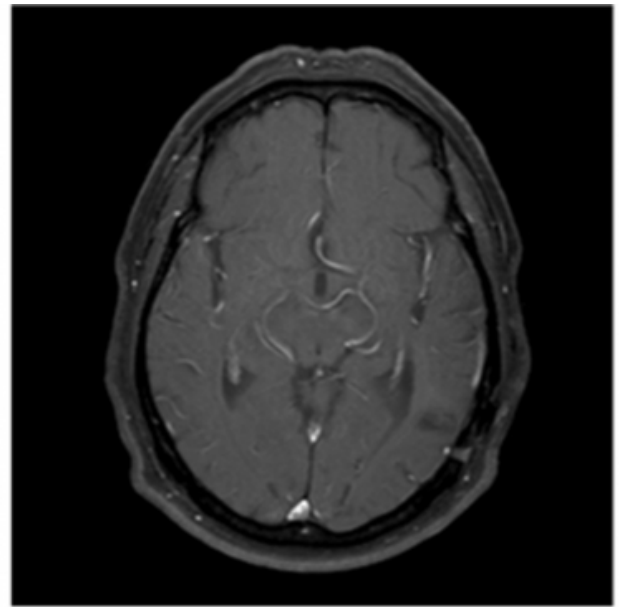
Axial T1 with Gadolinium MRI showing no evidence of recurrence at 3 year follow up.
